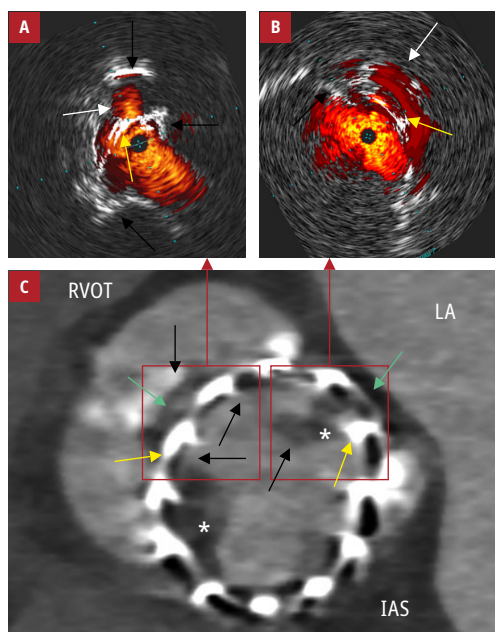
Corresponding postprocedural intravascular ultrasound (A and B) and late multislice computed tomography findings (C) in a patient after transcatheter aortic valve replacement. White arrows indicate the ChromaFlo signal, yellow arrows—the valve frame, blue arrows—the valve leaflets, the black arrow—calcium deposits, asterisks—hypoattenuated leaflet thickening, and green arrows—the sites of incomplete valve frame apposition, filled with either hypoattenuated tissue or contrast. Abbreviations: IAS, interatrial septum; LA, left atrium; RVOT, right ventricular outflow tract
